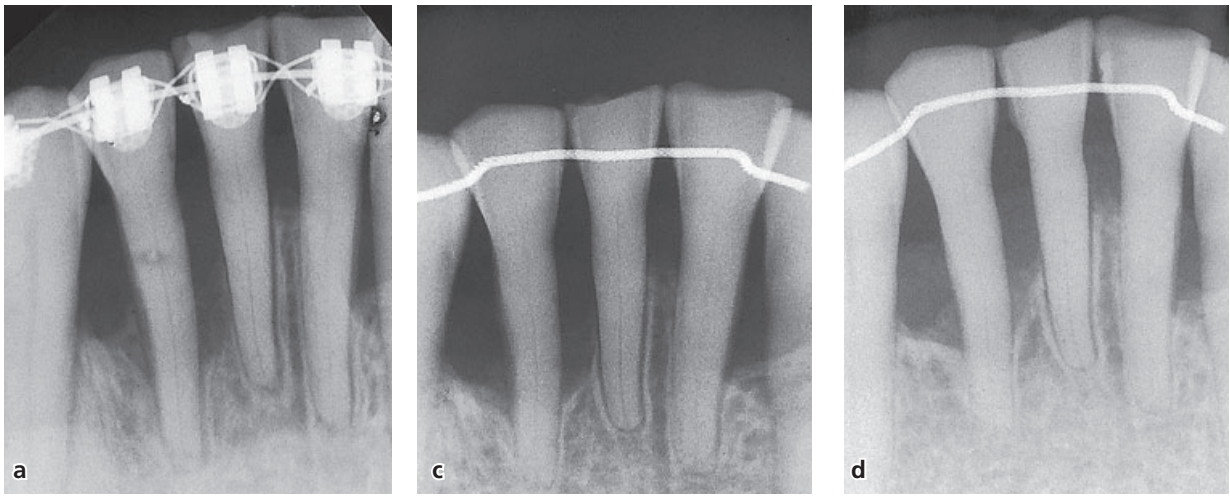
Post-treatment radiographic (a) and clinical (b) appearance of the mandibular dentition in the same patient as in Fig. 57-7 after periodontal and orthodontic treatment. The mandibular six-unit retainer bonded lingual retainer (b) concomitantly acts as a periodontal splint. Note signs of improvement of periodontal condition 7 and 9 years, respectively, after the orthodontic treatment (c,d), with marked crestal lamina dura contours.
